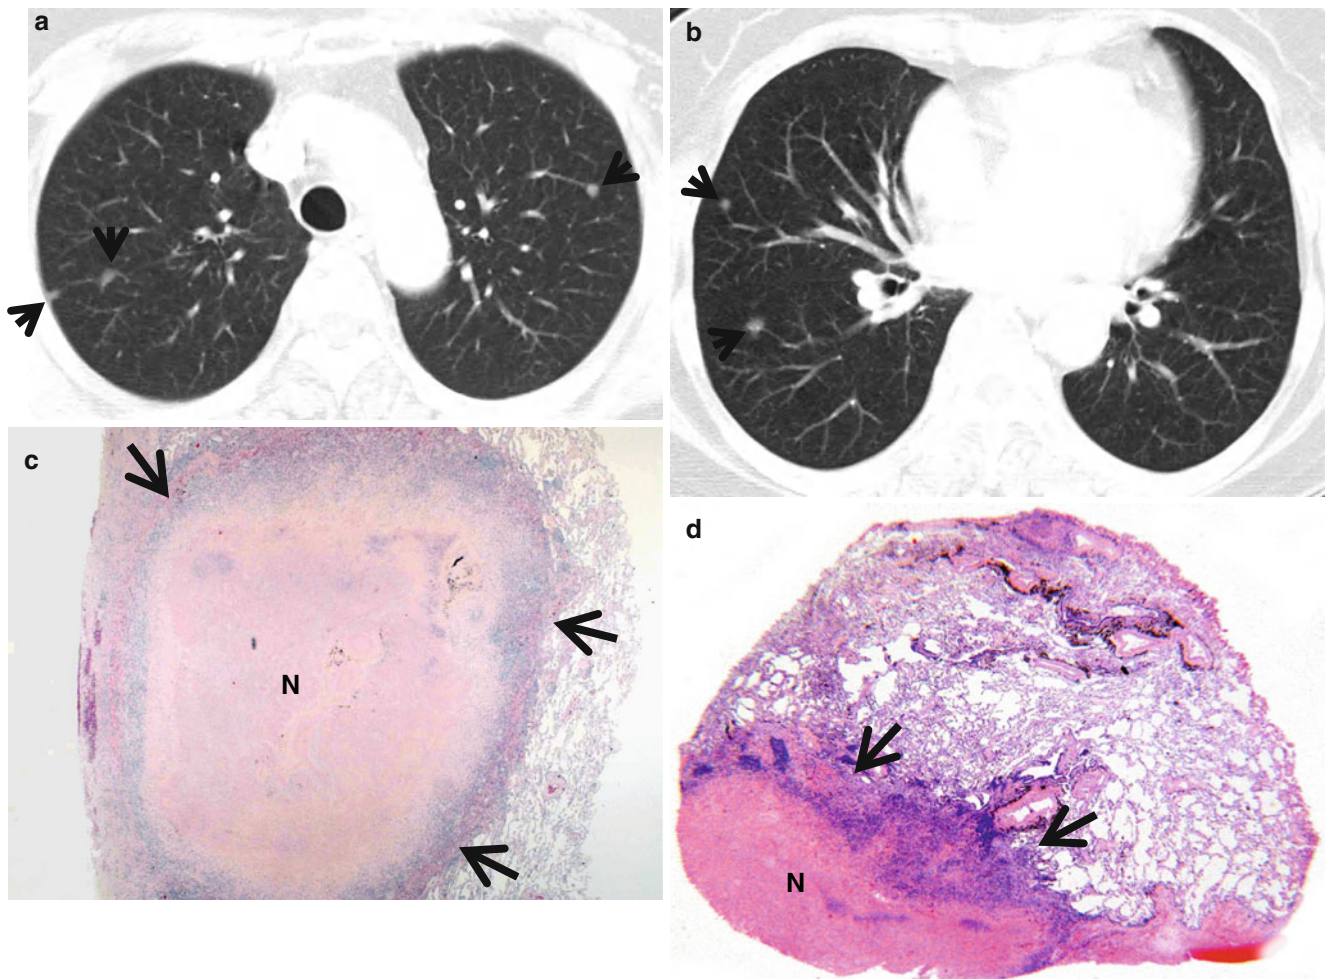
Rheumatoid nodules in a 70-year-old woman who has suffered from rheumatoid arthritis for 10 years. (a, b) Lung window images of CT scans (5.0-mm section thickness) obtained at levels of aortic arch (a) and basal trunks (b), respectively, show multiple small nodules (arrows) in both lungs. Mediastinal window images exhibit necrosis in central portion of nodules. (c) Low-magnification ($\times 4$)
